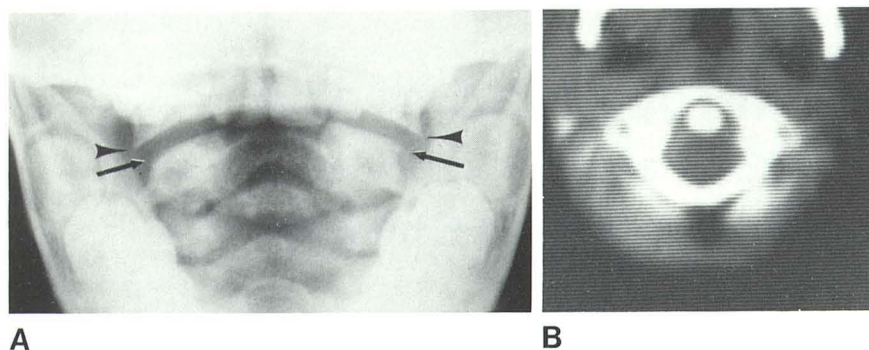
5-year-old boy. A, AP open-mouth view. Lower lateral margins of C1 (arrowheads) overhang articular surface of C2 (arrows). B, CT shows no fracture of C1.
